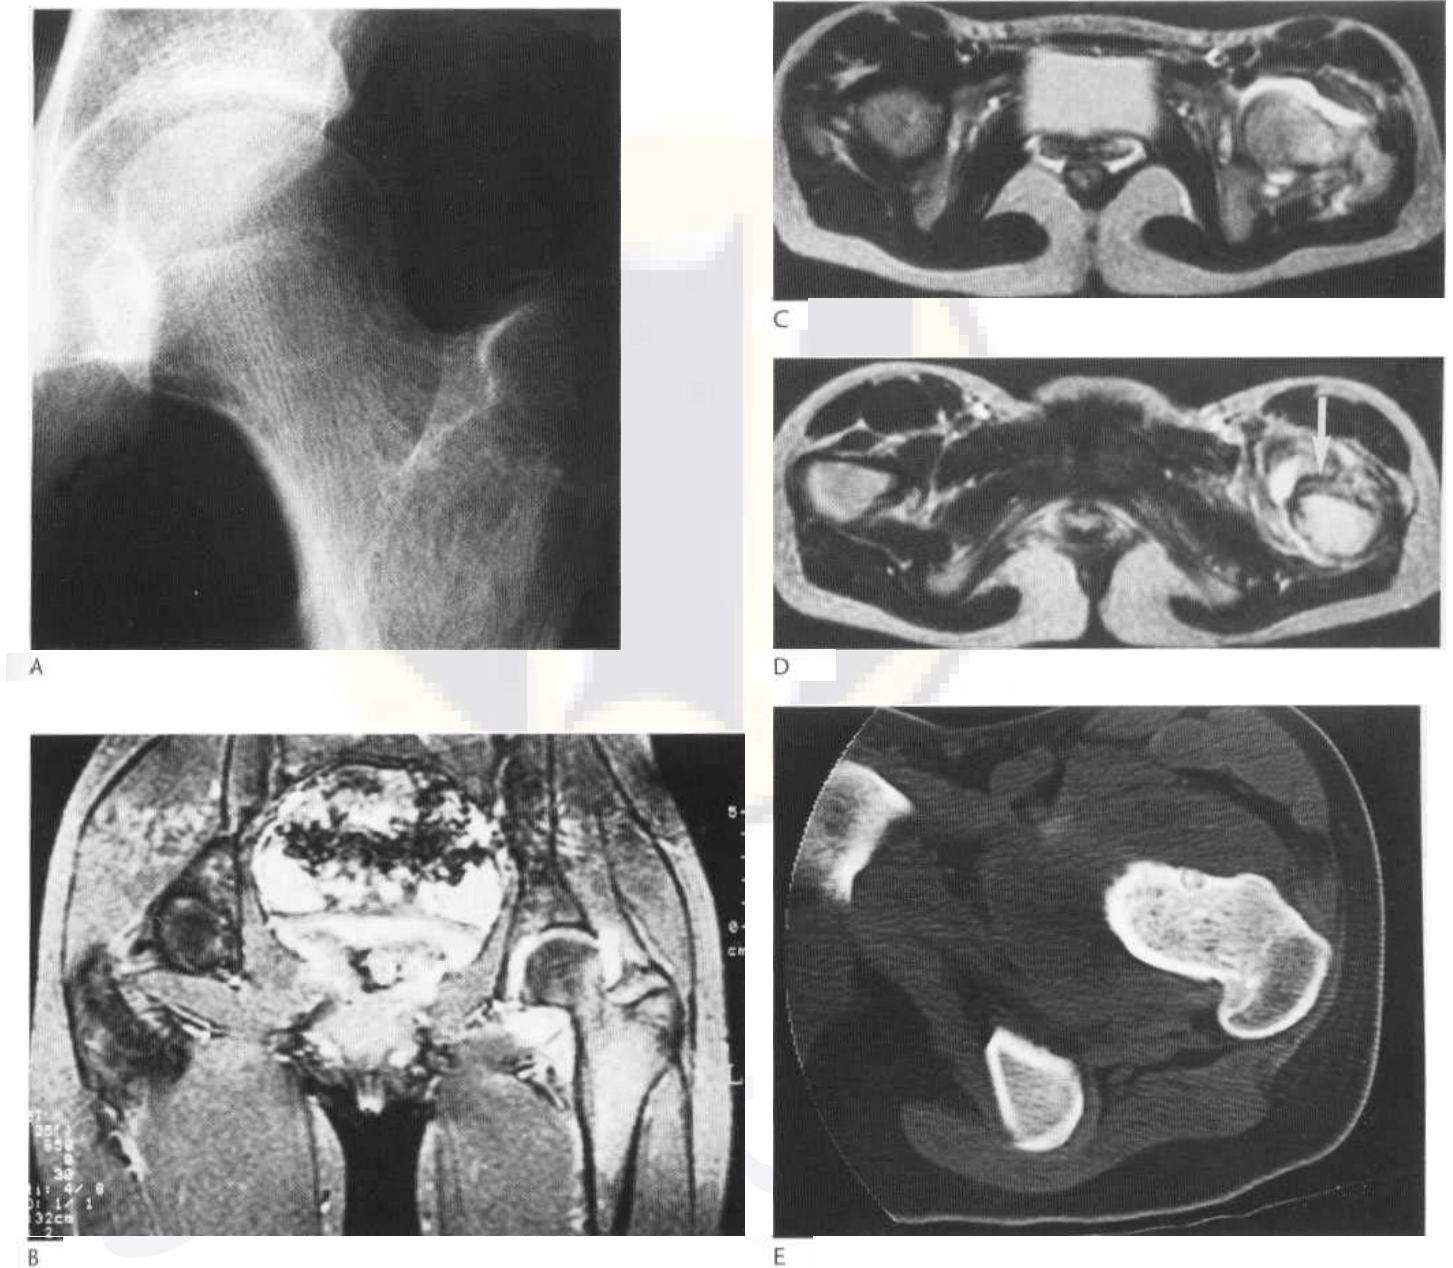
Osteoid osteoma in a young girl complaining of left hip and knee pain, initially thought to be due to juvenile onset rheumatoid arthritis. (A) A subtle radiolucency with a central density is shown in the basi-cervical region of the left femur. (B) Coronal FFE-T₂ MR section demonstrating high signal intensity within the proximal left femur due to considerable bone marrow oedema. A joint effusion is evident also together with some surrounding soft-tissue oedema. (C) Axial T₂-weighted MRI showing a prominent left hip joint effusion and bone marrow oedema within the femoral neck. The nidus, however, is not evident. (D) Axial T₂-weighted image through the proximal femur demonstrating more striking bone marrow oedema distal to the joint capsule and level of the osteoid osteoma. Periosteal new bone formation is also shown anteriorly (arrow). (E) Thin section CT showing the anteriorly located calcified nidus within the cortex of the femoral neck and the large joint effusion.
